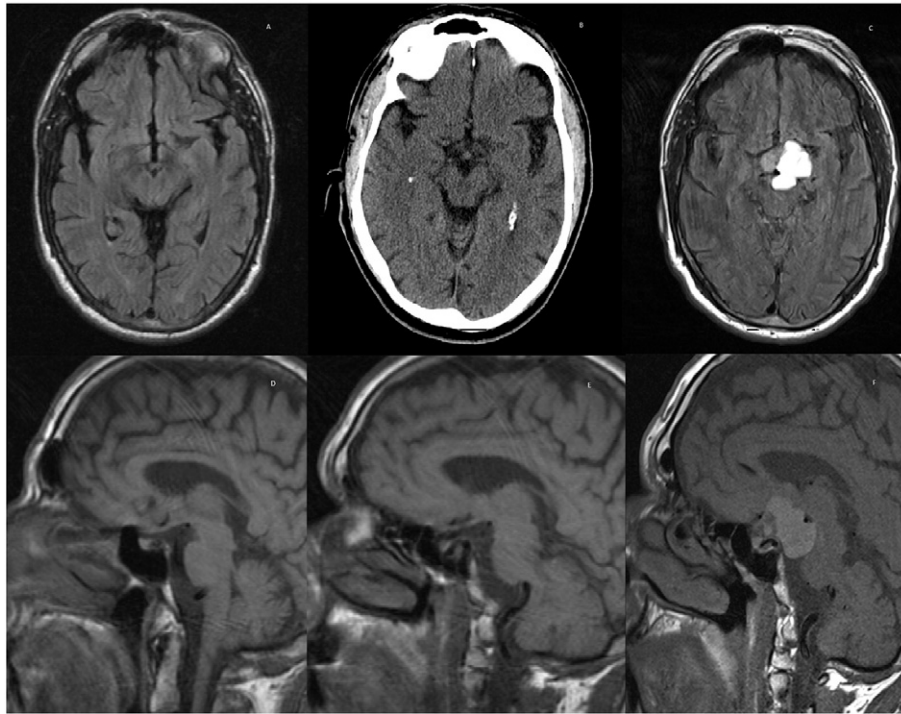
Axial unenhanced FLAIR MRI 7 years prior (A) and axial unenhanced CT of the brain 3 years prior to diagnosis (B). Axial FLAIR MRI showing the lesion at the time of diagnosis (C).
